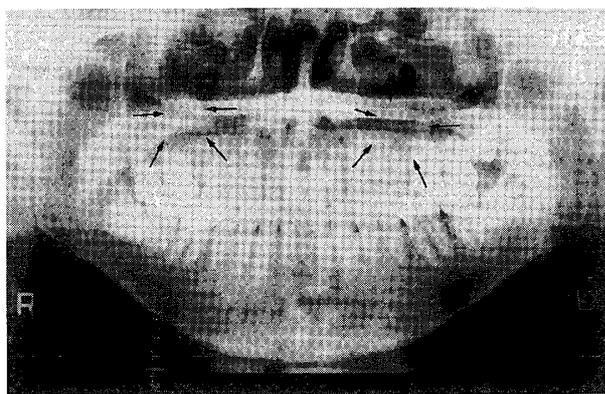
Panoramic radiograph showing a walnut-size, oval radiopacity at the bottom of the left maxillary antrum (arrows).
